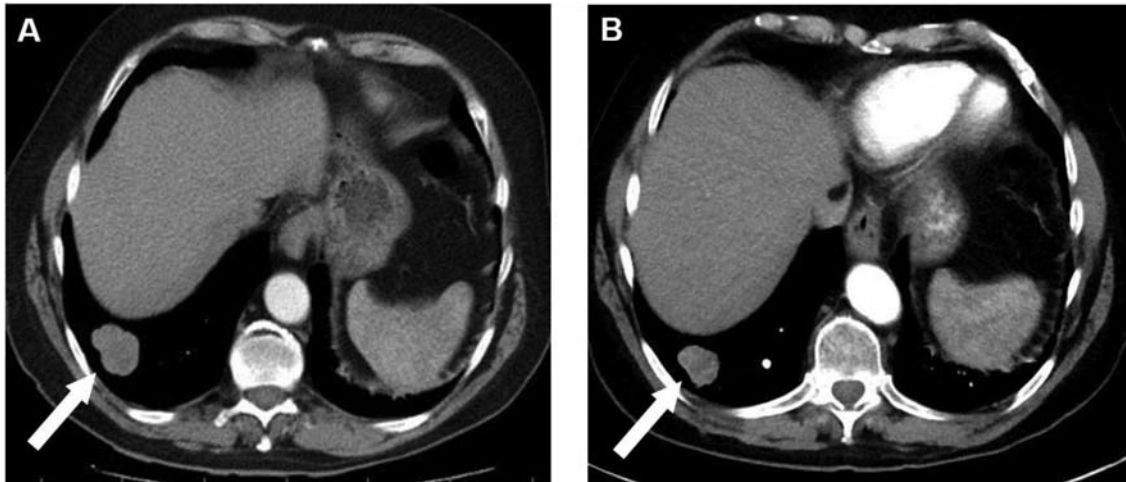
Chest contrast-enhanced computed tomography (CT) image data before and after treatment. A: Chest contrast-enhanced computed tomography (CT) horizontal plane of a 77-year-old male patient on 13th January 2014 showing a right intrapleural nodular tumor before starting treatment with GcMAF, STD/PDT, ozone therapy and TTF. B: Chest contrast-enhanced CT horizontal plane on 20th April 2015 showing a low-density area inside the tumor.
